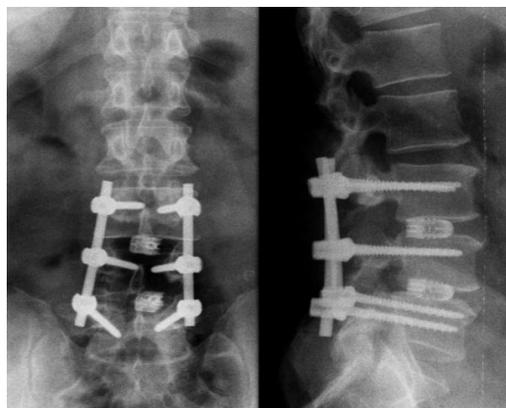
Control X-ray of the lumbar spine in two projections after installation of a trabecular cage with cells
